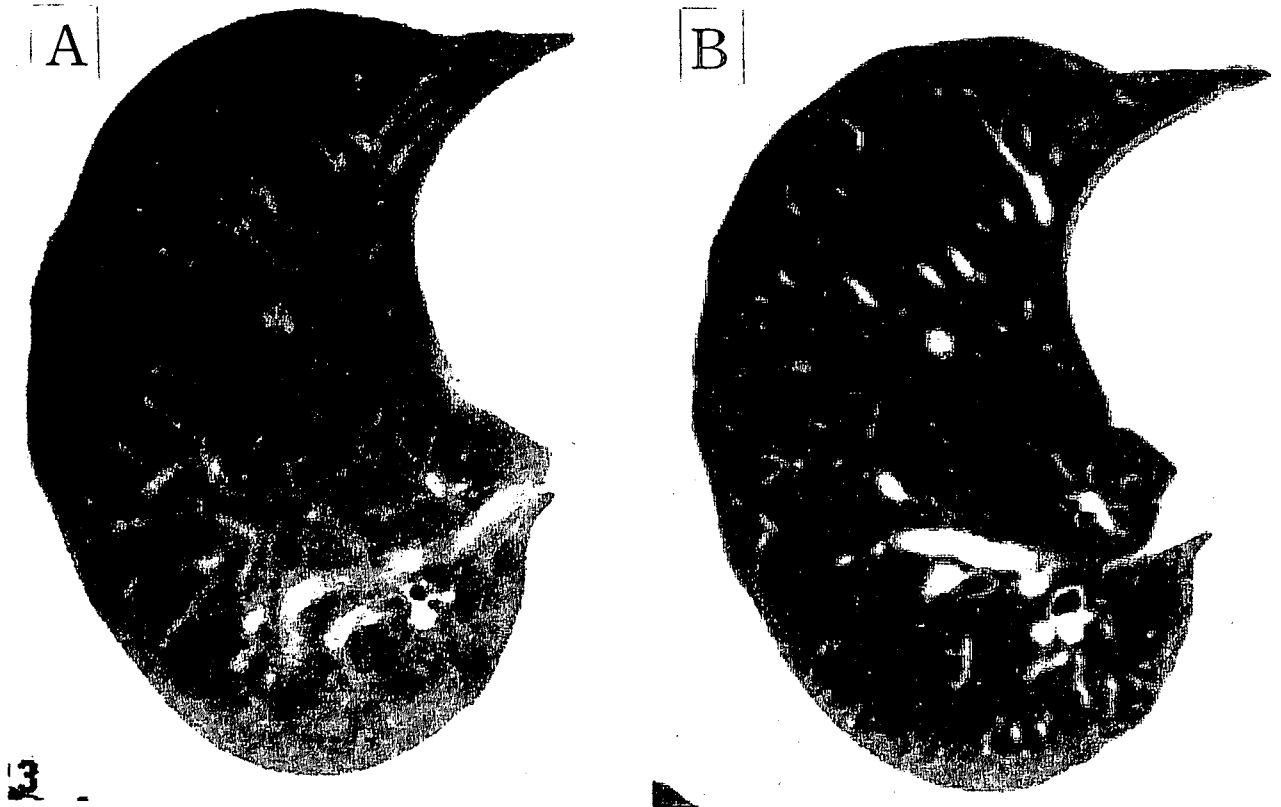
Case 11, a 56-year old woman. Left, A: the chest CT in September 1997 showing a small nodular shadow with a sharp border and solid-density in the right middle lobe. Right, B: the size of the mass on CT in March 1998 showing no change.
